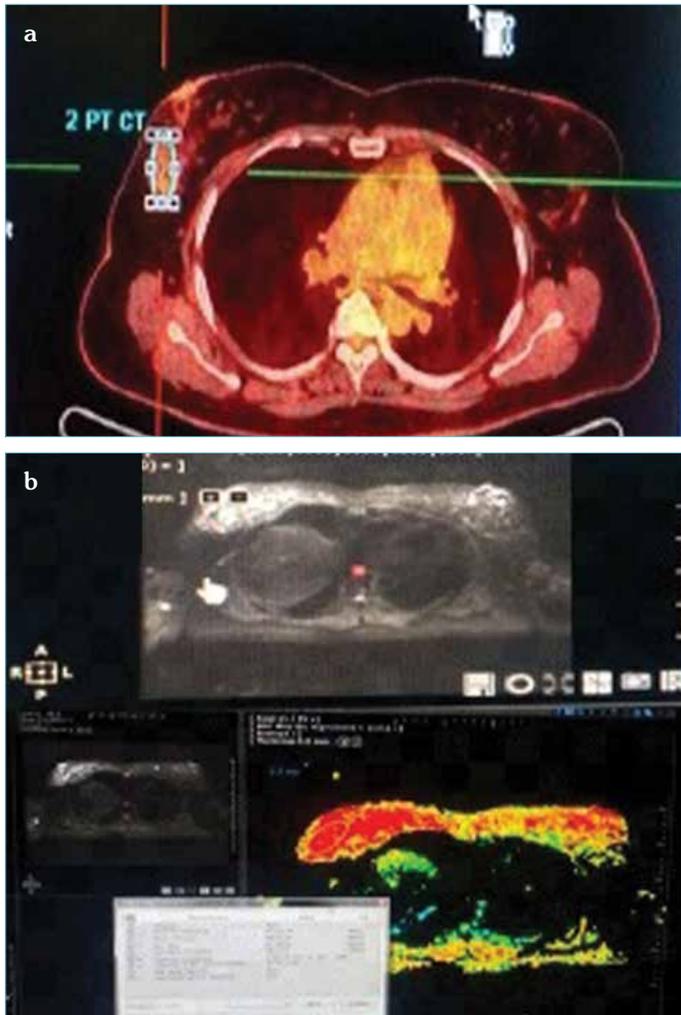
a,b. (a) Circular region of interest (diameter, 1.5 cm) was placed over the tumour in the slice with the maximum SUV: 2.33. (b) Circular region was drawn at the breast lesion with b value of 50 showed non-restricted whereas the b value of 900 showed restricted with ADC value of 0.66 which were malignancy
